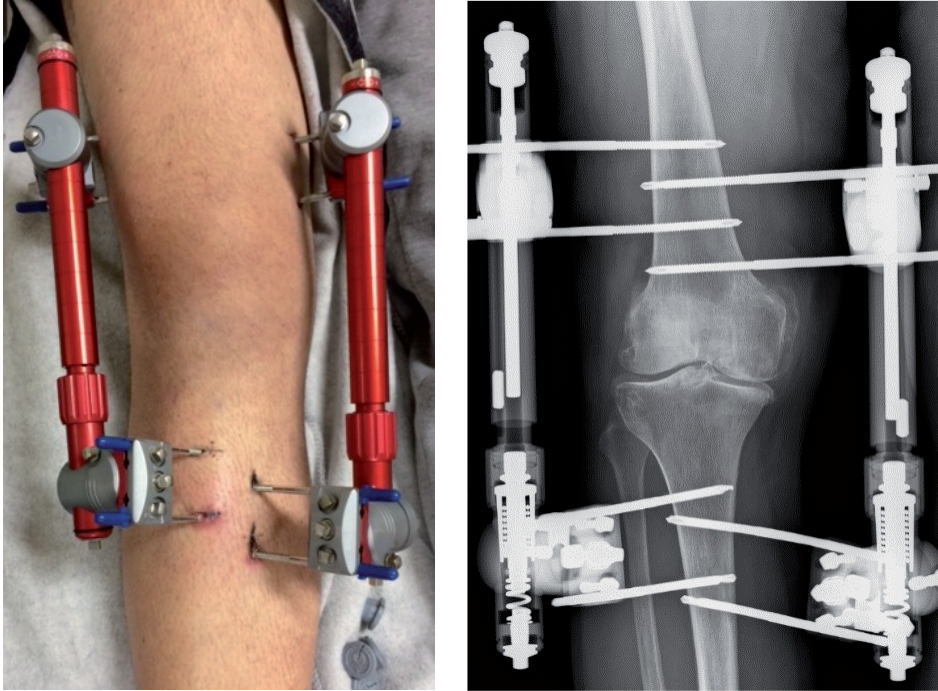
Example of the bilateral external fixation frame used for knee joint distraction treatment (left) and an example of a radiograph (right) during distraction treatment with five millimeters of distraction.
